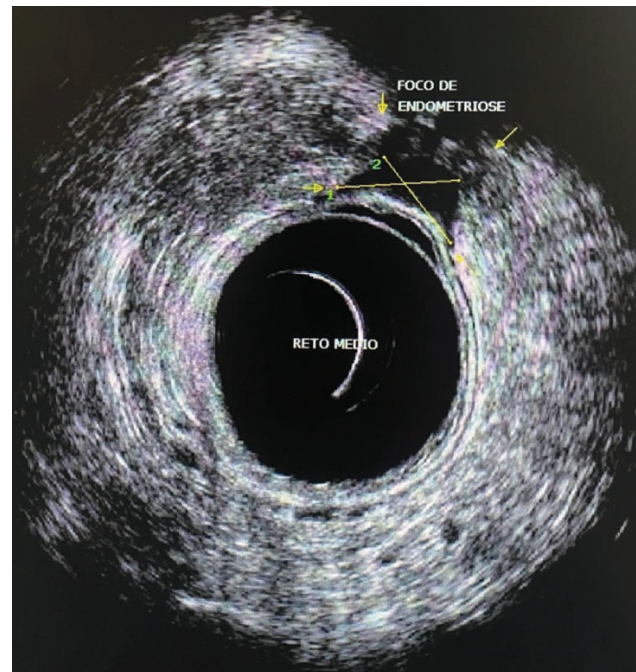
Endometriosis focus evaluated by three-dimensional endorectal ultrasound (axial view) involving the muscular layer of the rectum.
